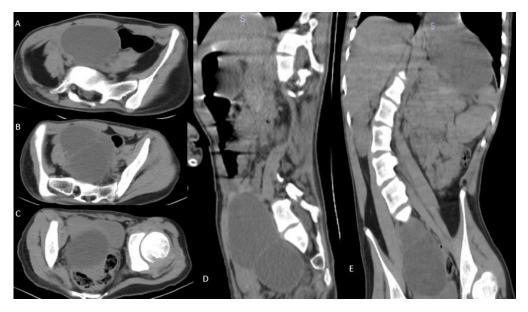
Abdominopelvic Computed Tomography Examination.
